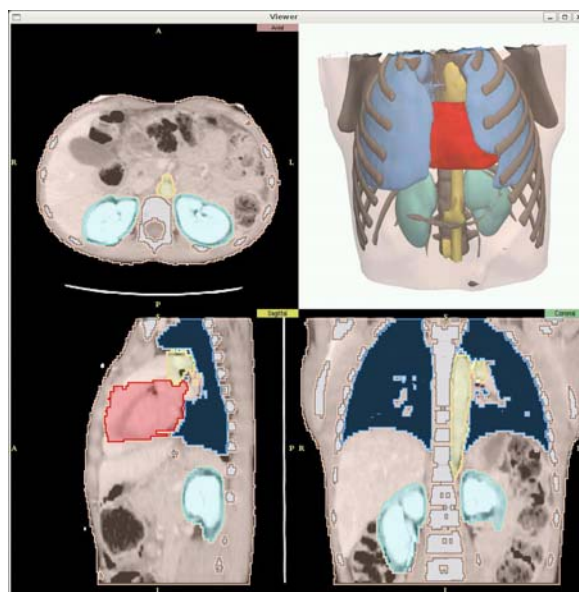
Automatic segmented CT volumes
